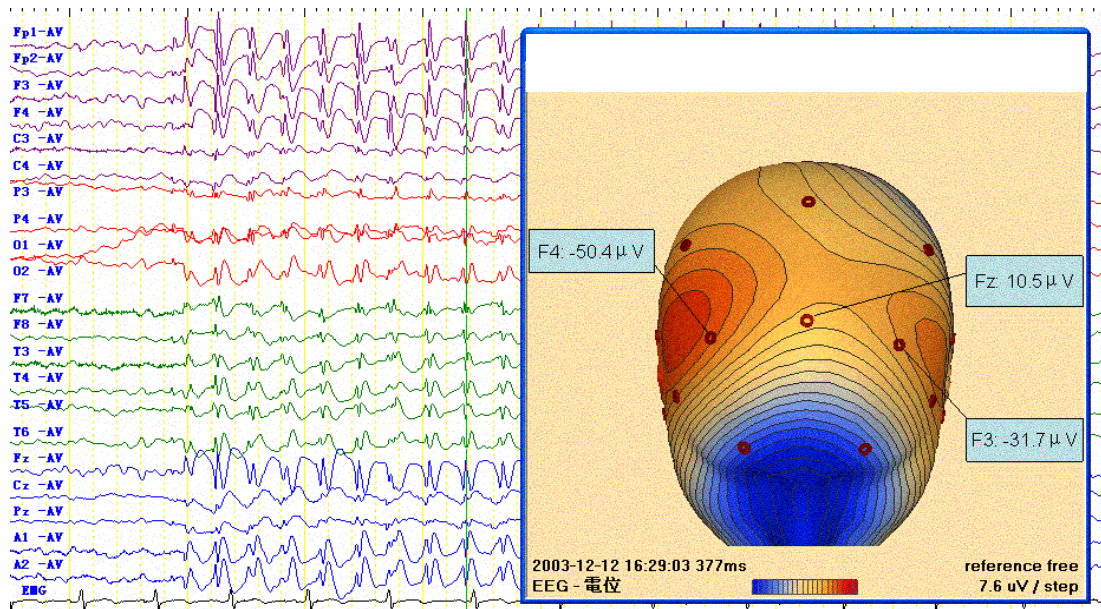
Stable SBS pattern with a double phase-reversal. At the age of 10, this 20-year-old male patient had absence-like seizures lasting 30 seconds 3-5 times a day and generalized tonic-clonic seizures preceded by head aversion to the right. Hyperperfusion was seen in the left frontal region on ictal SPECT and no abnormality on brain MRI. In transverse montage (a) there exist two phase reversals over left (F3) and right (F4) (arrows), which are reconfirmed by the longitudinal montage of the same burst (b) (arrows). (c) F3 and F4 were in the vicinity of two negative maxima in voltage topography of the same spike in average potential reference derivation.
